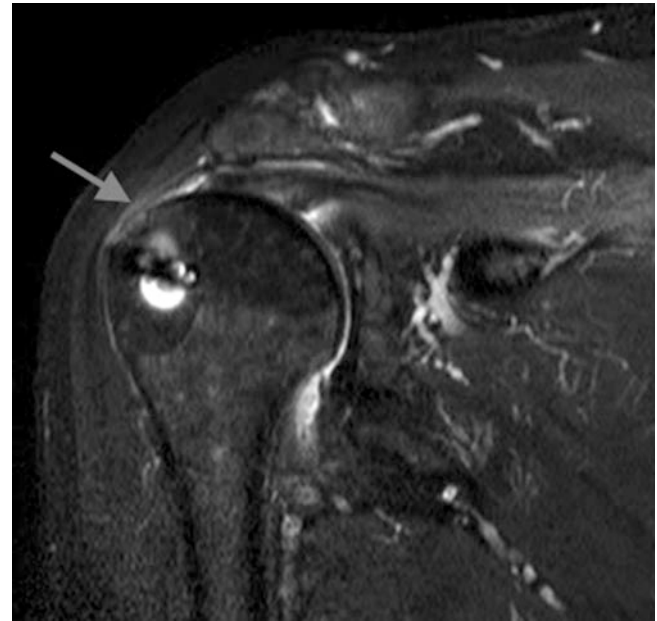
MRI image showing massive lesion of the supraspinatus tendon after surgical repair with proximal retraction (*gray arrow*)
